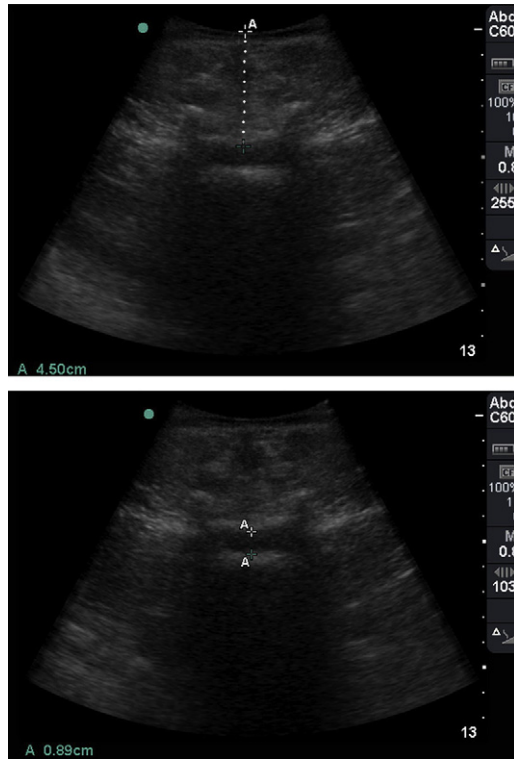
Estimation of the needle depth (*dotted line*) by ultrasound with the aid of the built-in caliper. The author recommends positioning the caliper at the inner side (ie, the deepest border of the ligamentum flavum–posterior dura mater unit) (*top image*). The built-in caliper can also measure the antero-posterior diameter of the dural sac (*bottom image*). (A) Position of caliper.
